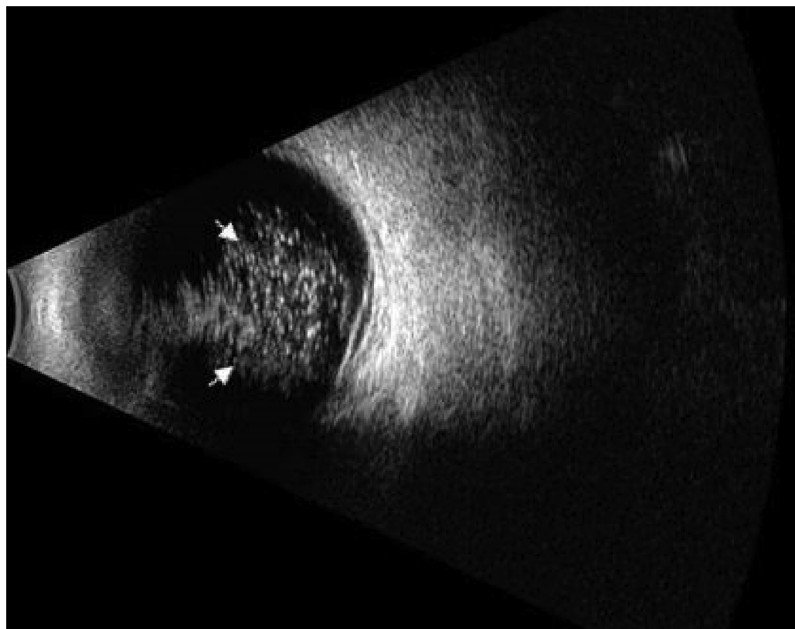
Ophthalmic ultrasound scan of a 25 year old female demonstrates diffused hyper-echogenic foci (arrows) that involved all the vitreous area and associated with AH.
